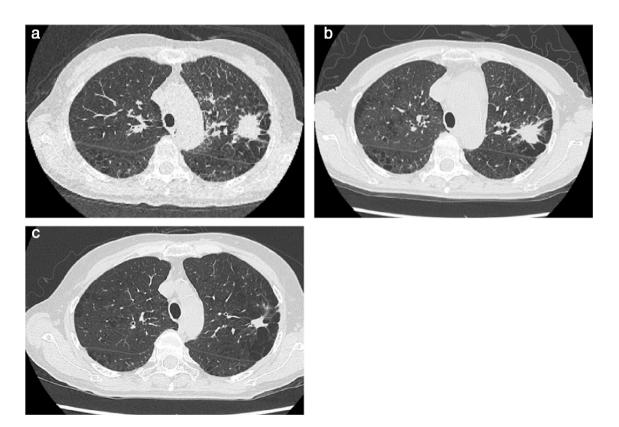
Serial chest computed tomography (CT) findings before and after pembrolizumab therapy. (a) Before pembrolizumab. (b) After three courses of pembrolizumab. (c) After nine courses of pembrolizumab.
